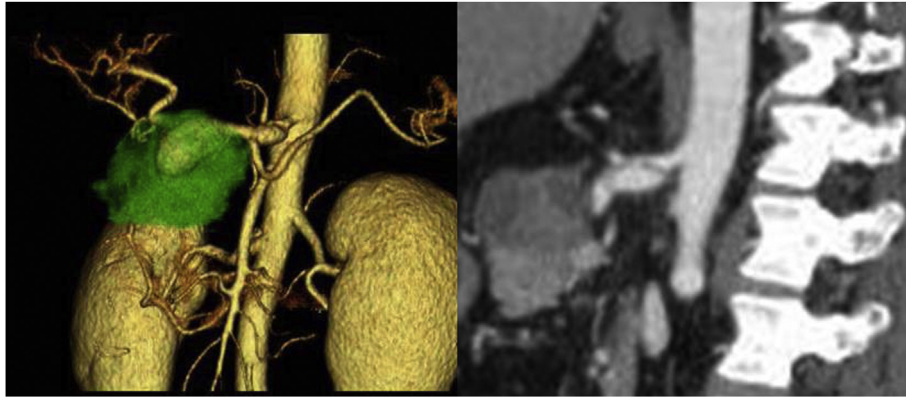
Contrast enhanced computed tomography showing a 6 cm common hepatic artery aneurysm and coeliac artery dissection.
